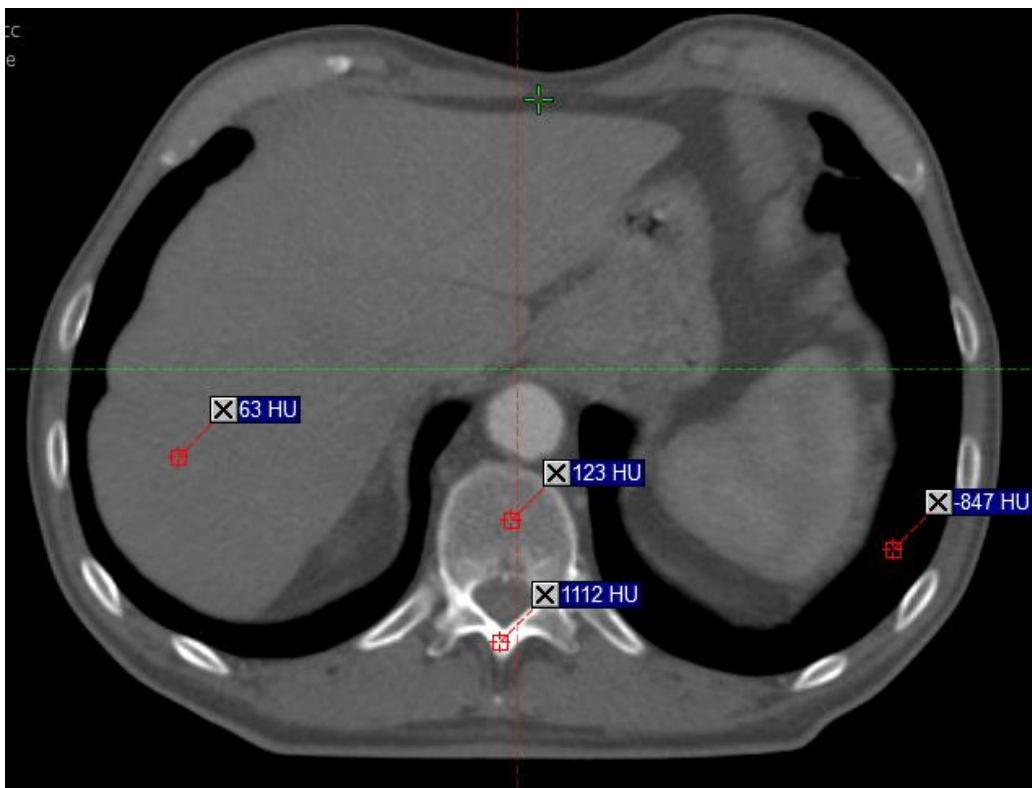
Axial computed tomography (CT) image through the upper part of the abdomen. The blue fields show examples of Hounsfield Units (HU) values in some pixels in the image. The image is from one of the study patients.
